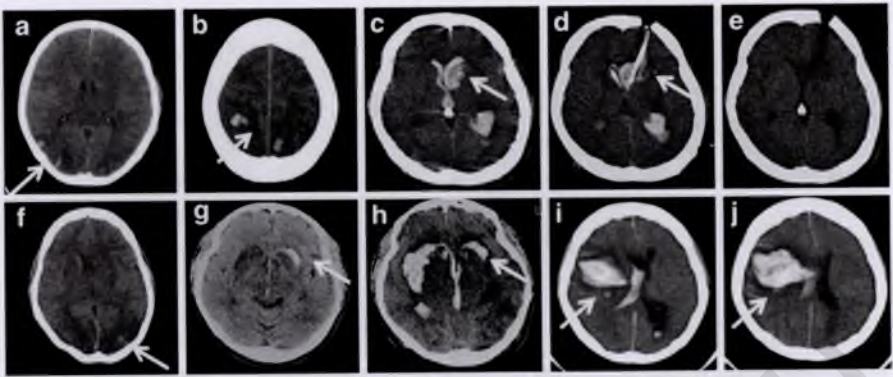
CT scans of pregnancy-associated stroke. (a, b) Case 2. A CT scan obtained before the patient underwent a cesarean section detected multifocal cerebral hemorrhaging and massive brain edema. (c–e) Case 3. A CT scan obtained 60 min after delivery (c) detected a cerebral hemorrhage in the left caudate nucleus and ventricular release. Further CT scans, which were acquired just after the endoscopic hematoma evacuation procedure (d) and 17 days after the operation (e), demonstrated that the surgery had been successful. (f) A 34-year-old Japanese primigravida woman who was complicated with preeclampsia and convulsions at 29 weeks' gestation. A hemorrhagic infarction was seen in the bilateral occipital regions on the day after the patient underwent a cesarean section. (g, h) A 27-year-old Japanese primigravida woman who was complicated with placental abruption and continuously impaired consciousness after a cesarean section performed at 33 weeks' gestation and subsequently died. Severe cerebral hemorrhaging in the bilateral caudate nuclei, ventricular release, and massive brain edema were observed on a CT scan performed after the cesarean section. (i, j) A 37-year-old Japanese primigravida woman who was complicated with convulsions, impaired consciousness, and HELLP syndrome at 33 weeks' gestation and subsequently died. Severe cerebral hemorrhaging in the right cortex, ventricular release, and massive brain edema were seen on a CT scan obtained 2 days after the patient underwent a cesarean section. Arrow, site of the hemorrhage
